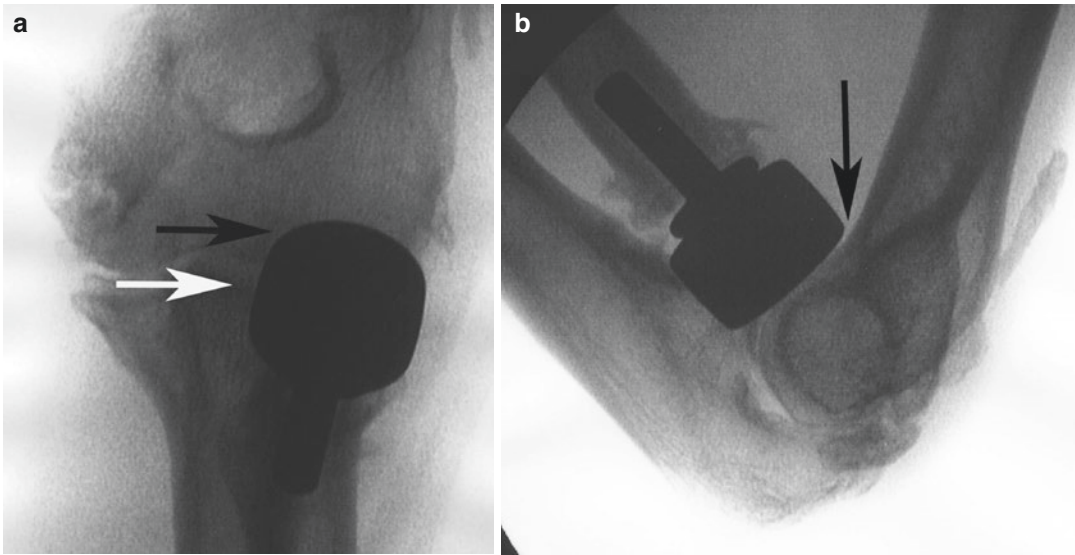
(a–b) Anteroposterior (a) and lateral (b) radiographs showing a large radial head implant that overstuffs the radiocapitellar joint. Note that the proximal margin of the radial head implant (black arrow) is too proximal to
